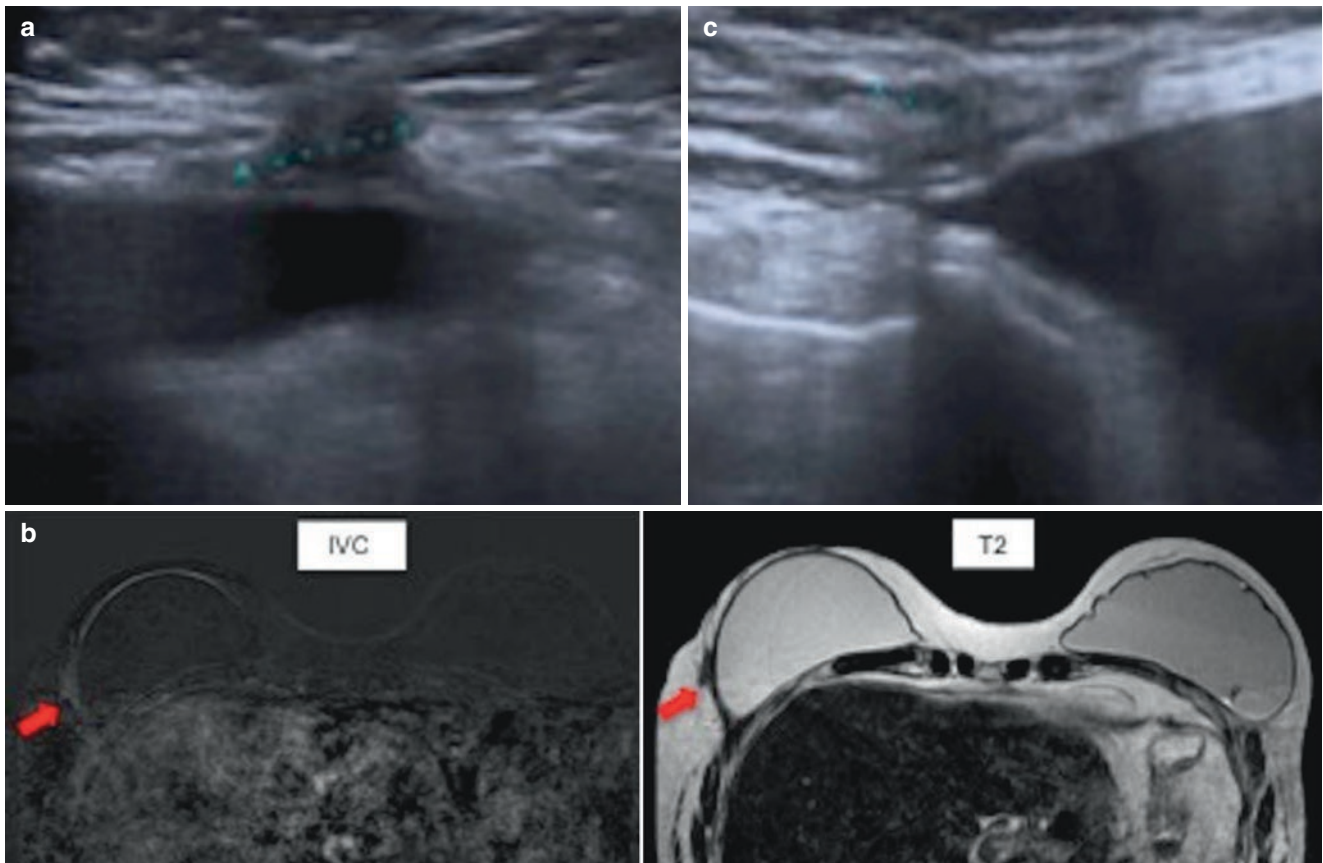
Patient with a personal history of bilateral mastectomy. The patient noted a lump in the LOQ of right breast. (a) Ultrasound showing an ill-defined margin lesion in that location, adjacent to the implant, highly suggestive of malignancy. A breast MRI was performed due to difficulty in differentiating the suspicious finding from scar. (b) The lesion seen on ultrasound shows slight enhancement but irregular
